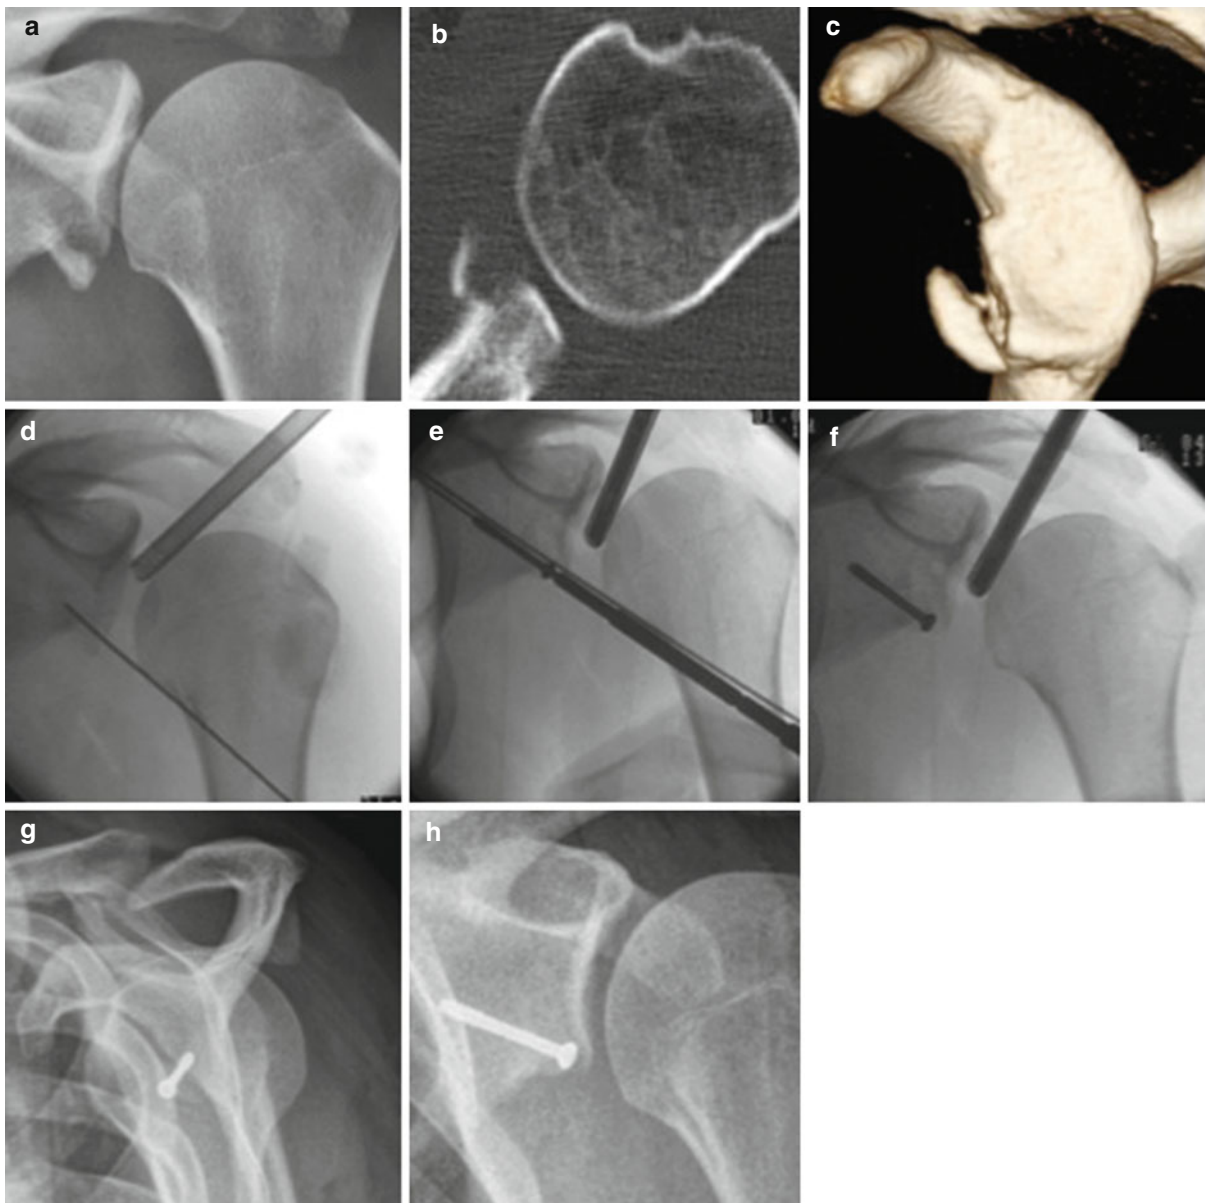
Arthroscopic guided screw fixation of an anterior Bankart fracture. Preoperative diagnostic using (a) plain X-ray. (b) axial CT-scan. (c) 3D-volume rendering of CT scans. (d–f)
